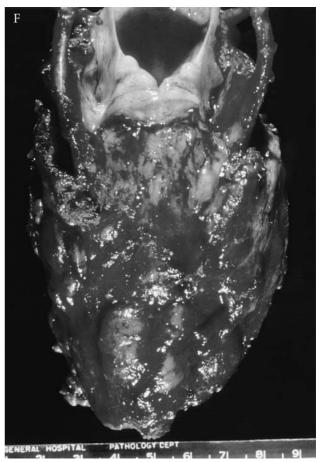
Very extensive adenoid cystic carcinoma which prohibited salvage of the larynx in a 39-year-old man. Diagnosis had failed to be made at an initial presentation with hoarseness and a paralyzed vocal cord 2 years earlier. Now he had dysphagia, dyspnea on effort, but no hemoptysis. The extent of laryngeal involvement precluded any attempt to salvage it. The patient was considered a candidate for cervicomediastinal exenteration (laryngotracheal pharyngoesophageal resection with mediastinal tracheostomy and esophageal replacement). Endoscopic views. A, Laryngoscopy. Tumor invades the subglottis up to the conus elasticus and fills the posterior commissure (arrow). B, Esophagoscopy shows submucosal tumor invading the esophagus anteriorly. C, Tomogram. Anteroposterior view. Tumor encircles the subglottis, paralyzes the vocal cord, and invades the upper trachea (open arrow). The solid arrow marks the glottis. D, Computed tomography delineation of tumor. Tumor infiltration of the larynx. The arch of thyroid cartilage is anterior, the remnant of cricoid posterior.
